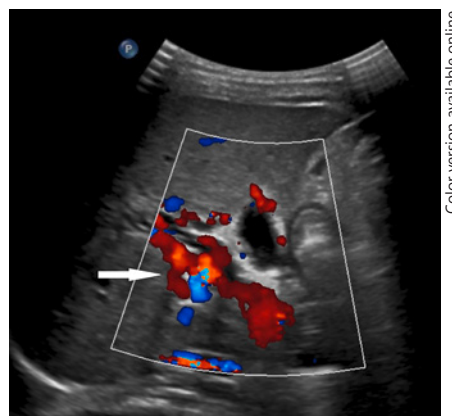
Color Doppler ultrasound showing multiple serpiginous vessels in the periportal region, indicative of cavernous transformation.
